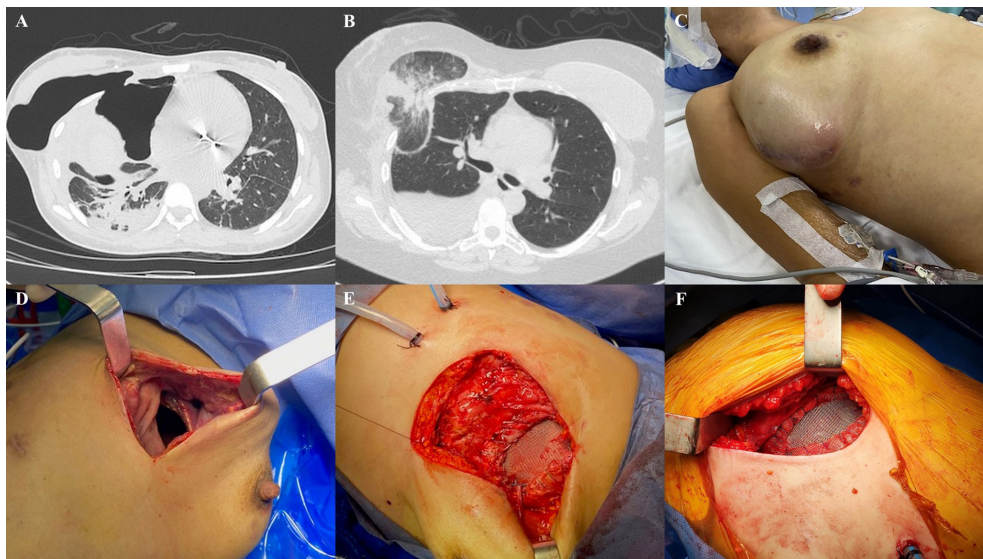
A-B) Chest computed tomography showing a right-sided intercostal defect with a pneumothorax and protrusion of lung parenchyma into the herniated space. C) Preoperative image showing a bulging mass into the right chest of the patient. D) Right intercostal defect after lung reduction revealing wide intercostal space. E) Direct open mesh hernia repair. F) Post-video-assisted thoracoscopic mesh lung hernia repair.
